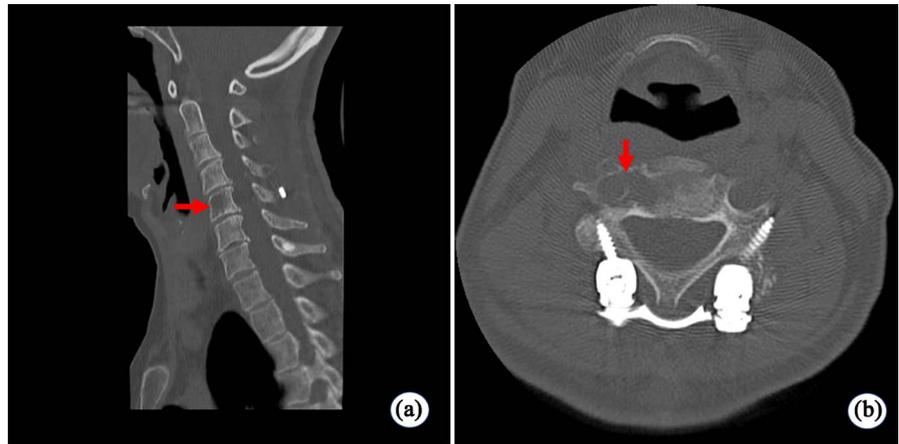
Follow-up CT performed at three weeks after posterior cervical spine decompression and fusion. Note the osteolytic lesion (arrow) in the C5 vertebra on the (a) sagittal and (b) axial views of the cervical spine. The osteolytic lesion was enlarged before the surgery for cervical posterior decompression and fusion, suggesting a malignant tumor.
